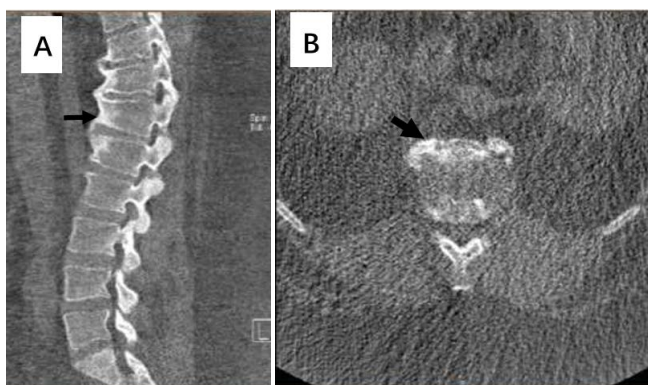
Anterior ankyloses of the T10 to L1 on CT scan images (arrows) with old wedged compression fractures and increased kyphosis (A) and axial view showing that bony fusion between disc spaces from T10 to L1 (B).
